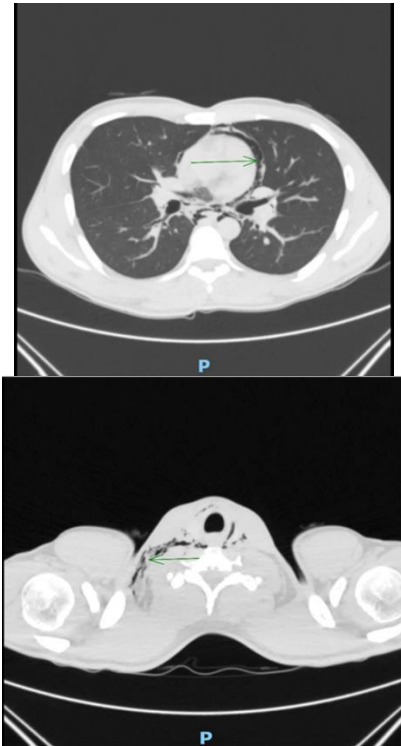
Non-contrast CT of the chest and neck demonstrating pneumomediastinum, presence of sharp lines of increased lucency within the mediastinum (marked with green arrow) and subcutaneous emphysema (hypodense gas denoted by green arrow).
